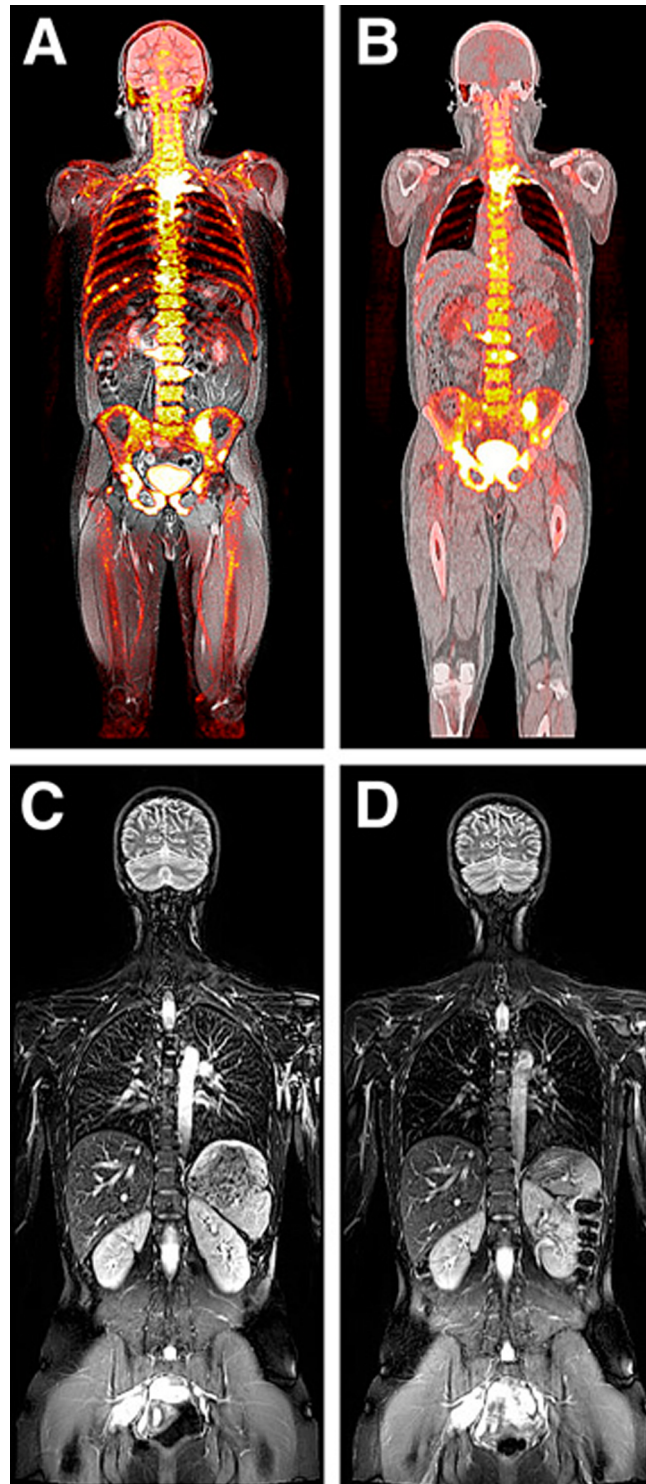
Fused views of a whole-body ^{18}F -fluoride scan of the same patient, acquired with the Biograph mMR PET/MR (A) and the Biograph PET/CT (B). Biograph mMR (C) and Verio (D) T2-weighted coronal views of a healthy volunteer.
